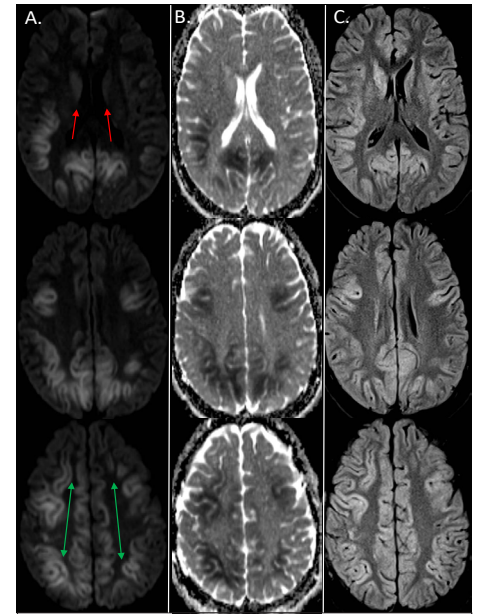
Axial slices of DWI (A.), ADC (B.) and T2 FLAIR (C.) MRI correlated sequences obtained 5 days after cardiac arrest, demonstrating bilateral (right greater than left) T2 hyperintensities of the basal ganglia (red arrows), as well as diffusion restriction of the parietal, occipital and frontal cortices (green arrows).
